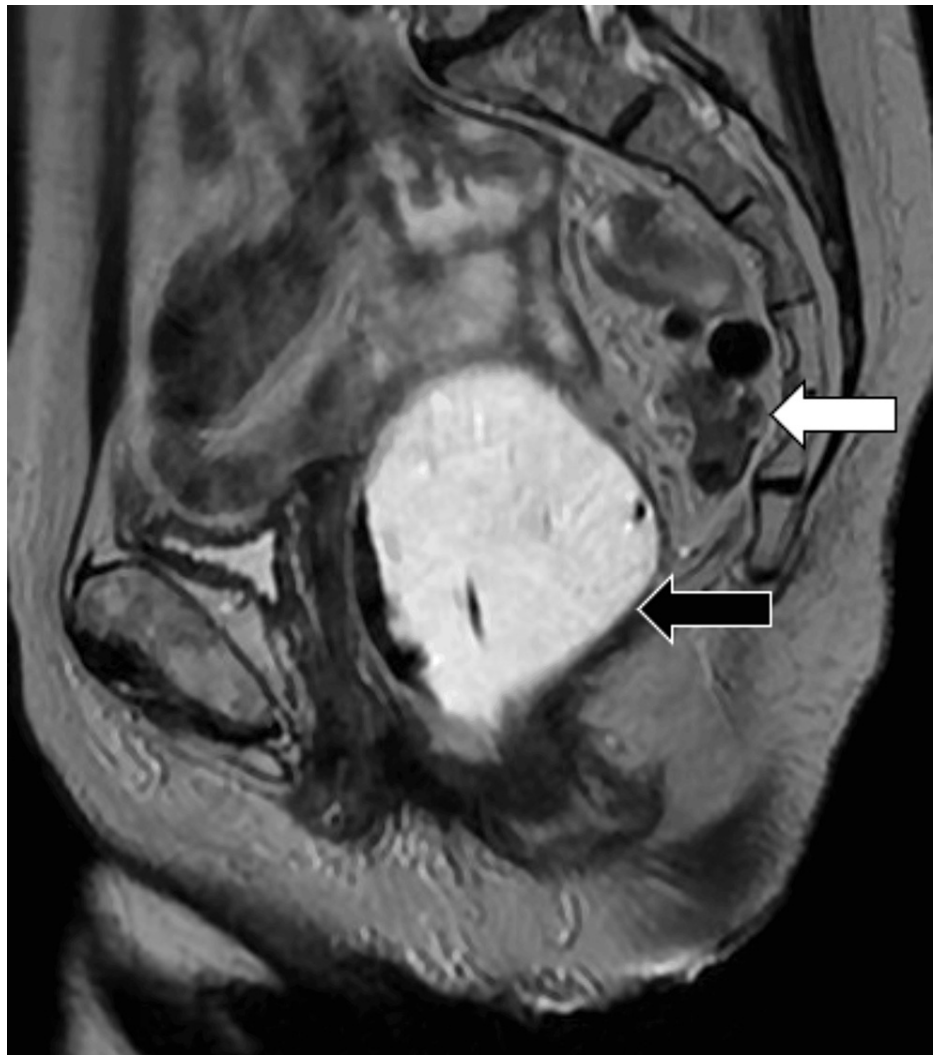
Sagittal T2-weighted image of the pelvis showing the sigmoid colon (white arrow) in the presacral space – posterior to the rectum (black arrow) during the rest phase of MR defecography. The rectum is distended with T2 hyperintense gel per MR defecography protocol.
